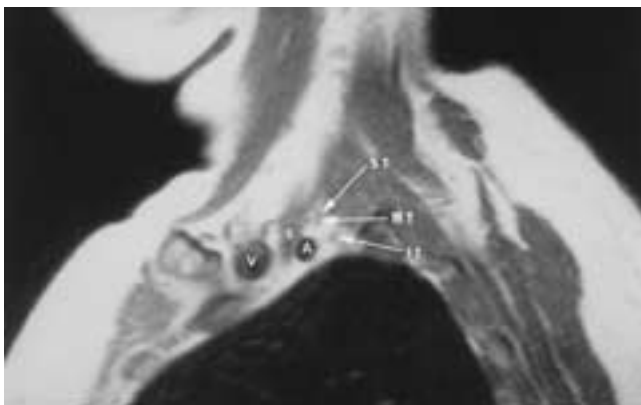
Sagittal MR T1-weighted image shows the trunks of the brachial plexus. The superior trunk (ST) and middle trunk (MT) are posterior superior and the inferior trunk (IT) is directly posterior to the subclavian artery (A). The subclavian vein (V) is anterior to the anterior scalene muscle (S).
